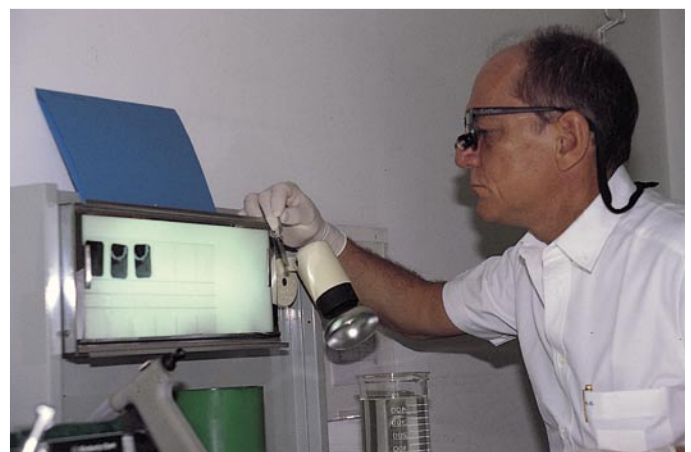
After the radiograph has been properly fixed, it can be read by transmitted light on a light box.
